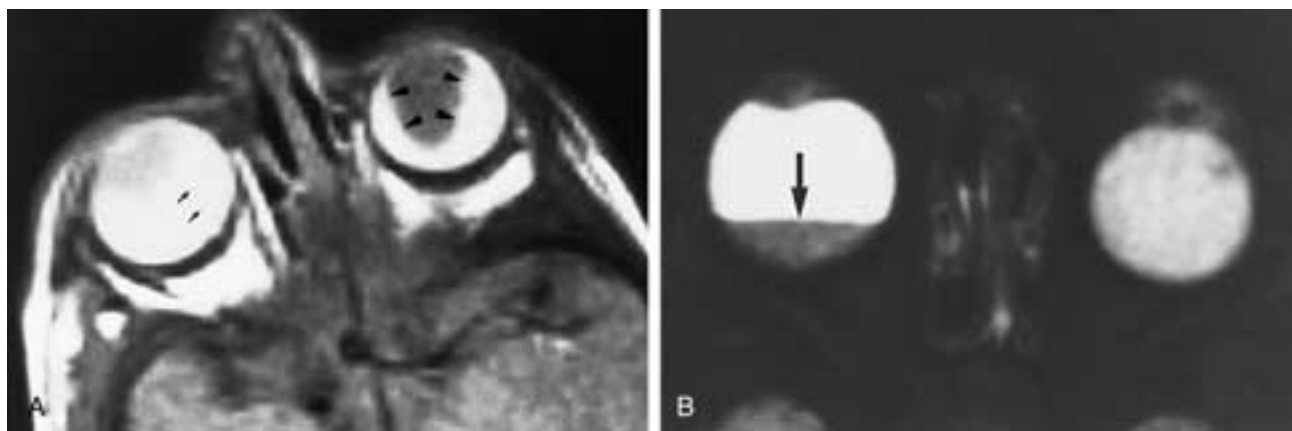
Warburg's syndrome. A, Axial T1-weighted MR image shows subretinal effusion with a detached retina (arrows) of the left eye. Hyperintensity of the right globe is caused by chronic hemorrhage in the subhyaloid or subretinal space. Note the congenitally nonattached retina or Cloquet's canal and the abnormal retrolental soft tissue. B, Axial T1-weighted MR image obtained 4 months later reveals progression of disease in both eyes with a fluid-fluid level (arrow) caused by chronic (hyperintense) and acute (hypointense) hemorrhage in the subhyaloid or subretinal space.
